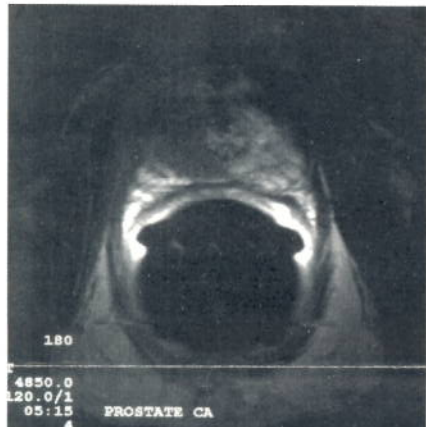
A. Turbo Spin Echo axial T2-weighted (TR 4850, TE 120) endorectal coil image. The low signal nodule in the brighter peripheral zone is typical of prostate cancer.
